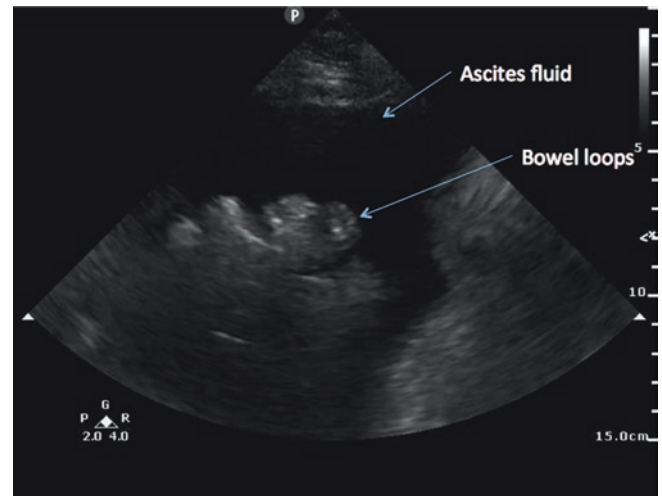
Abdominal ultrasound in a patient with ascites. Ascitic fluid can be easily seen on bedside ultrasound as echo-free or hypoechoic (black) space in the abdominal cavity. Normal appearing bowel loops are also visualized. Ultrasound allows for safe sampling of the ascitic fluid for both diagnostic and therapeutic purposes. See also Video 37.18
